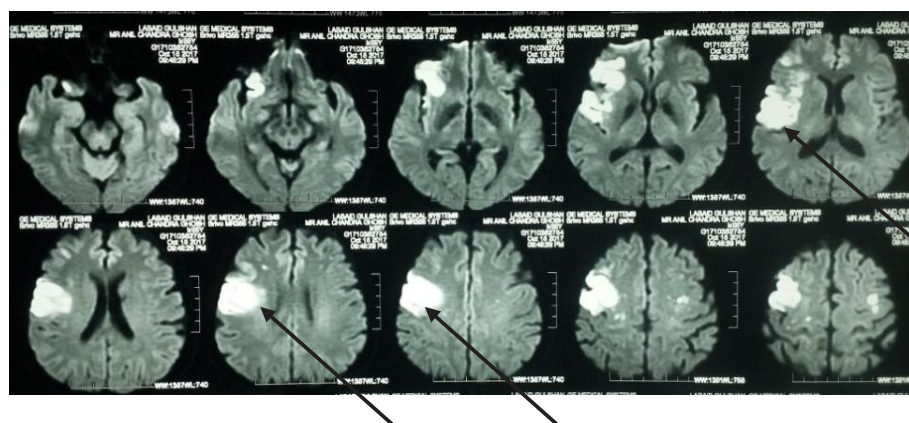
MRI of a patient of LAA (arrow showed infarction in both cortical and subcortical area which was >1.5 cm)
